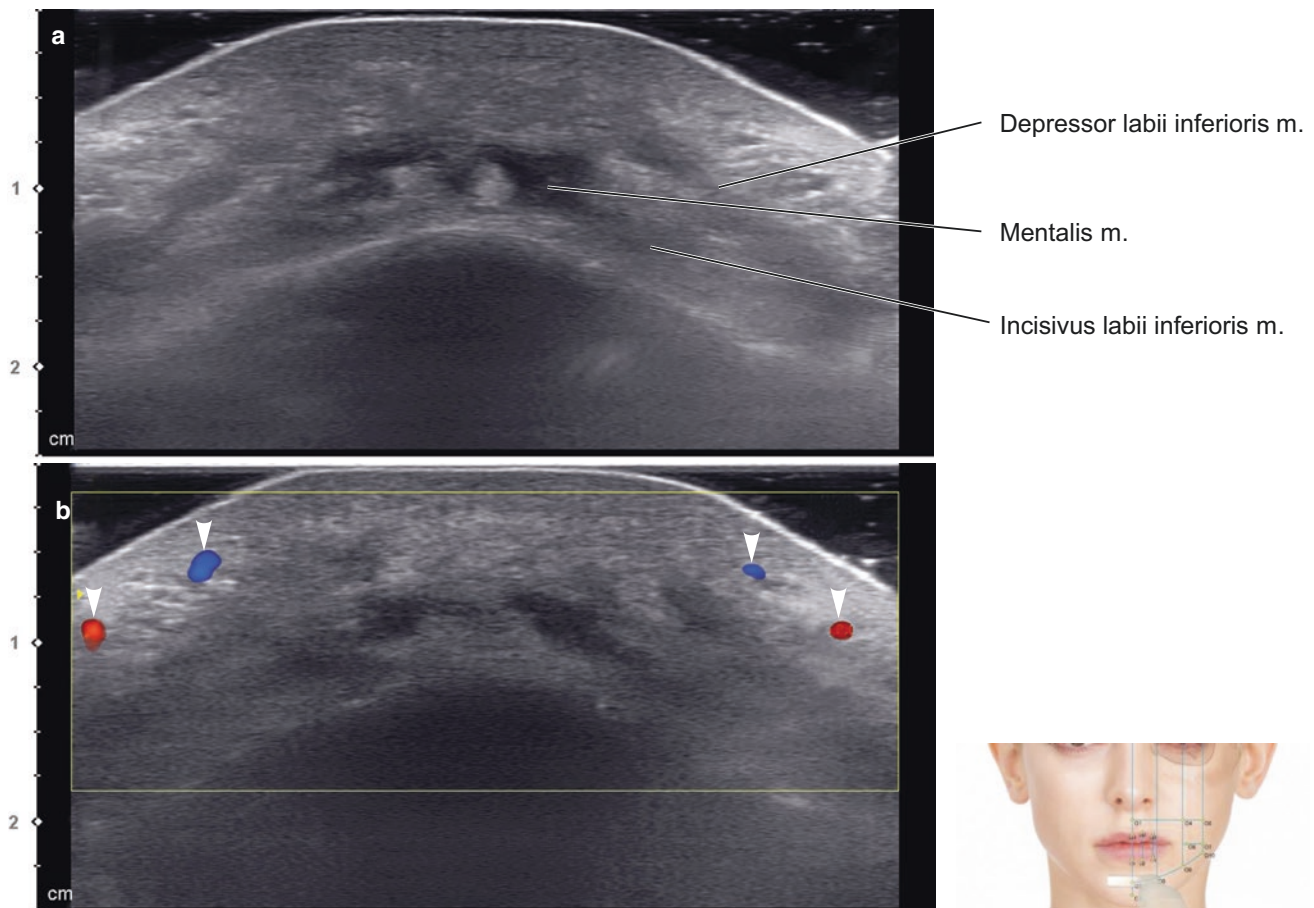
Ultrasonography on the midpoint between Li1 and gnathion (O2). (a) B mode (transverse view, 15 MHz by linear transducer) and (b) Doppler mode (transverse view, 15 MHz by linear transducer)
